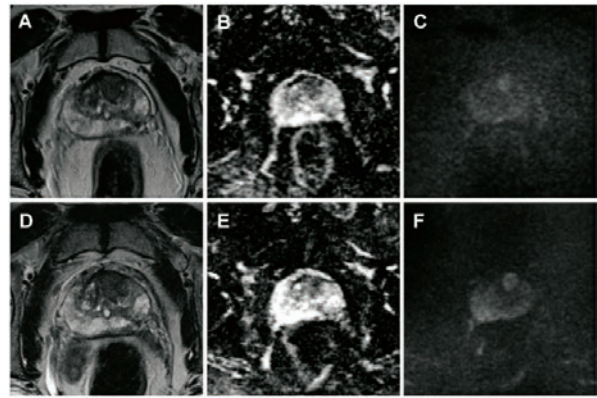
An example of the quality of the images used in the research. Images of A (T2W), B (ADC map) and C (DWI) obtained on MRI 1.5T and D (T2W), E (ADC map) and F (DWI) obtained on MRI 3T. High b-value images (1000 s/mm²) obtained on the 3T MRI (F) are qualitatively superior to the obtained image on the 1.5T MRI.
